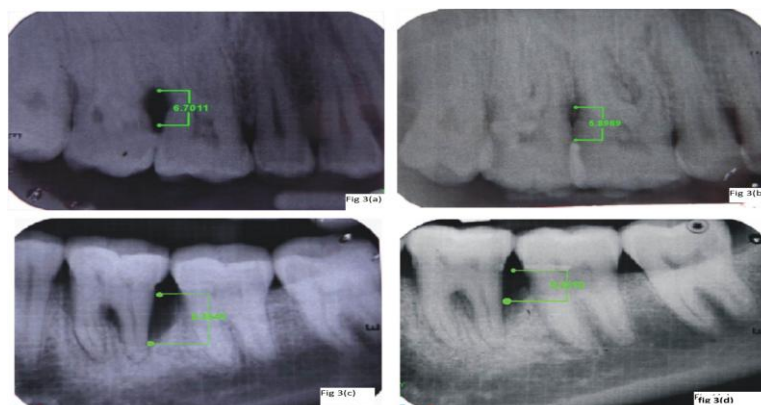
3 (a) IOPA x-ray of PRF site at baseline; (b) IOPA x-ray of PRF site at 6 months; (c) IOPA x-ray of Perioglas® site at baseline; (d) IOPA x-ray of Perioglas® site at 6 months.
